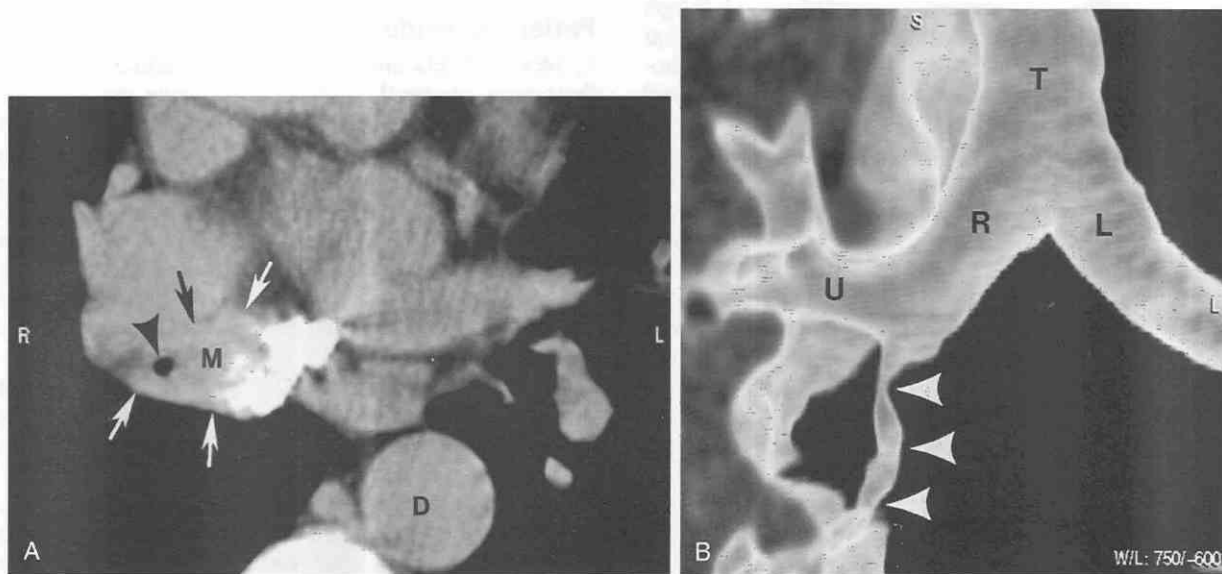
Fibrosing mediastinitis. *A*, Axial CT shows marked narrowing of bronchus intermedius (arrowhead) by soft tissue attenuation mass (M) (arrows). Note extensive subcarinal calcification. D, descending aorta. *B*, Volume-rendered shaded-surface display shows long-segment irregular narrowing of bronchus intermedius (arrowheads). Three-dimensional reconstructions can facilitate assessment and treatment of airway stenoses. L, left main bronchus; R, right main bronchus; T, trachea; U, right upper lobe bronchus.
